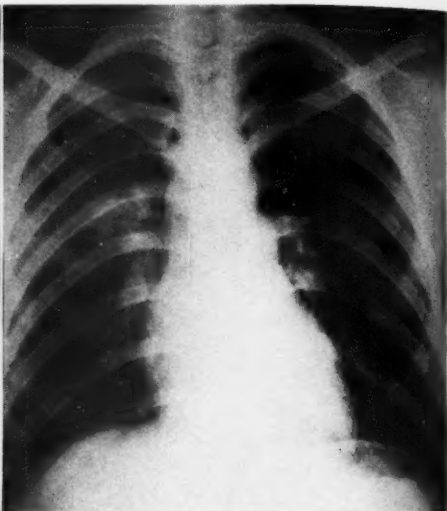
Case 6: Roentgenogram taken on fourteenth day of illness. Lesion on right is parenchymal. Lateral projection showed it posterior to hilum.
